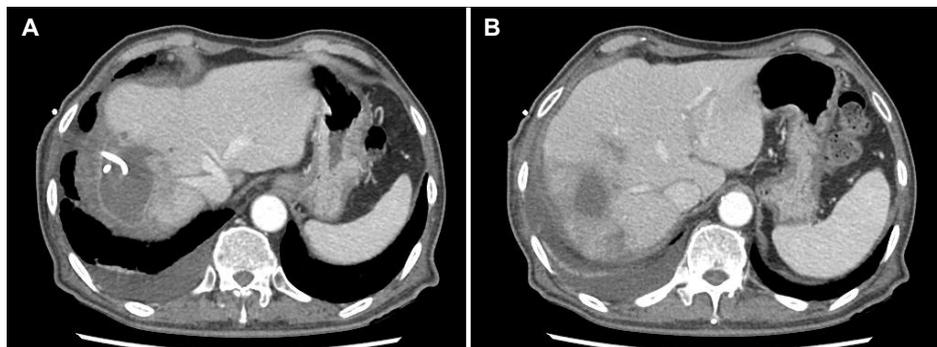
Computed tomography (CT) scan of the abdomen. (A, B) On hospital 44, the CT scan shows a significant size reduction of the abscess and diminished fluid collection.
